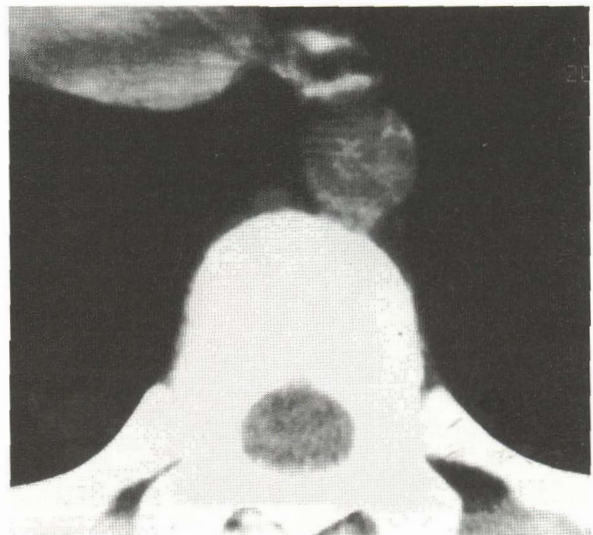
Grade II thoracic ependymoma. Serial axial postmyelogram CT scans at the levels of a T7, b T11, c T12, and d L1. Extensive neoplastic enlargement of the thoracic spinal cord (courtesy of Prof. J.-C. Froment)
